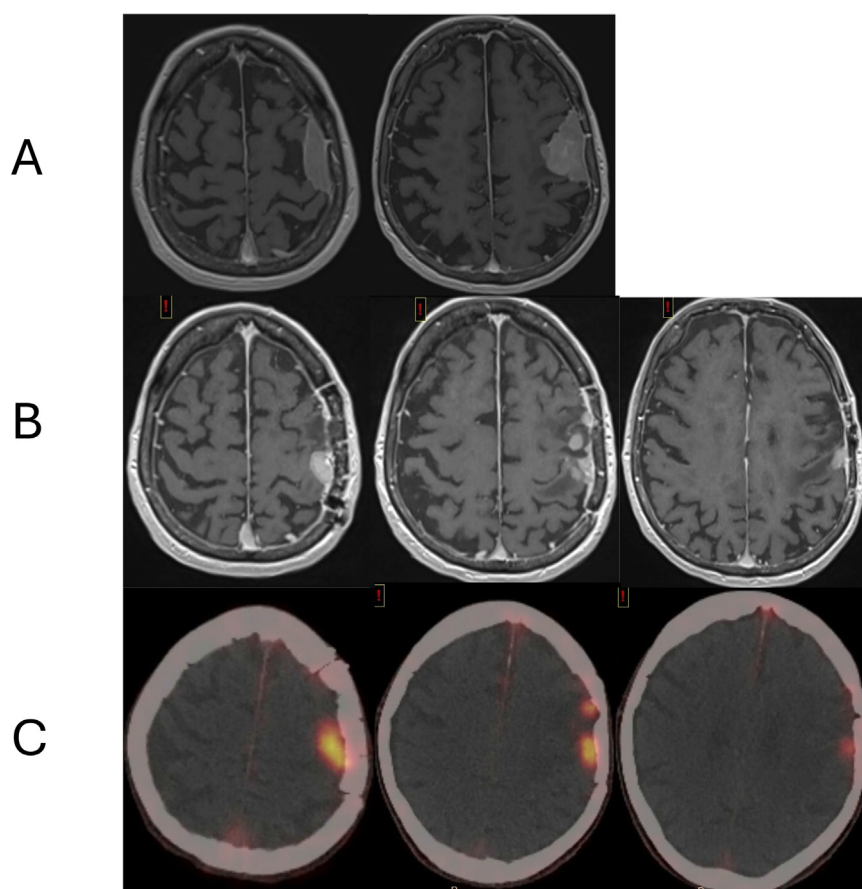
Case 3-Grade 1 meningioma with regrowth. (A) Preoperative MRI. (B) Postoperative MRI. (C) Postoperative PET. *Abbreviations:* MRI = magnetic resonance imaging; PET = positron emission tomography.
